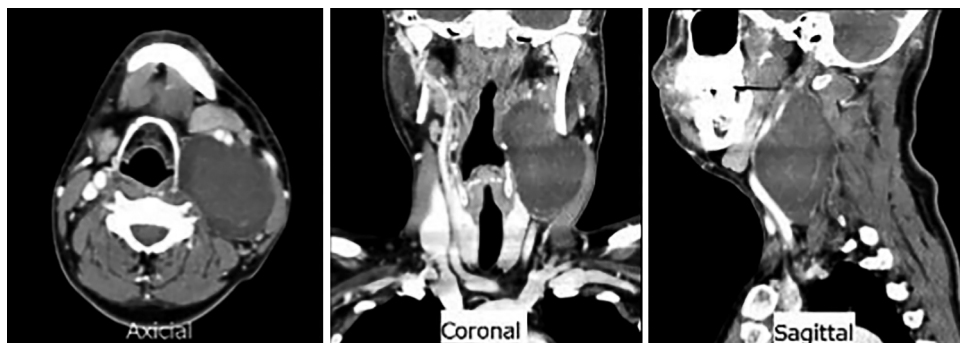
Contrast-enhanced computed tomography. A bulky tumor is located behind the common carotid artery on the left side of the neck. The tumor size is 100 × 50 mm, and the carotid artery has shifted forward.
